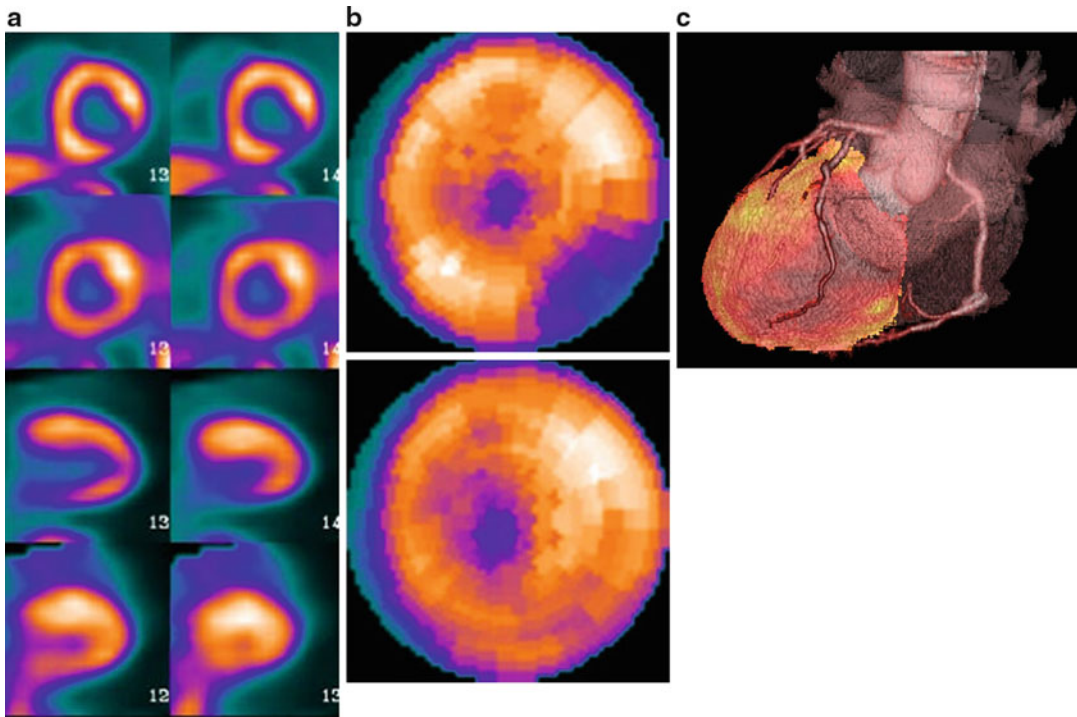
Integrated PET/CT images demonstrating a subtending coronary artery responsible for a reversible perfusion defect. A reversible perfusion defect is observed at the inferolateral wall on tomographic images (a) and on
